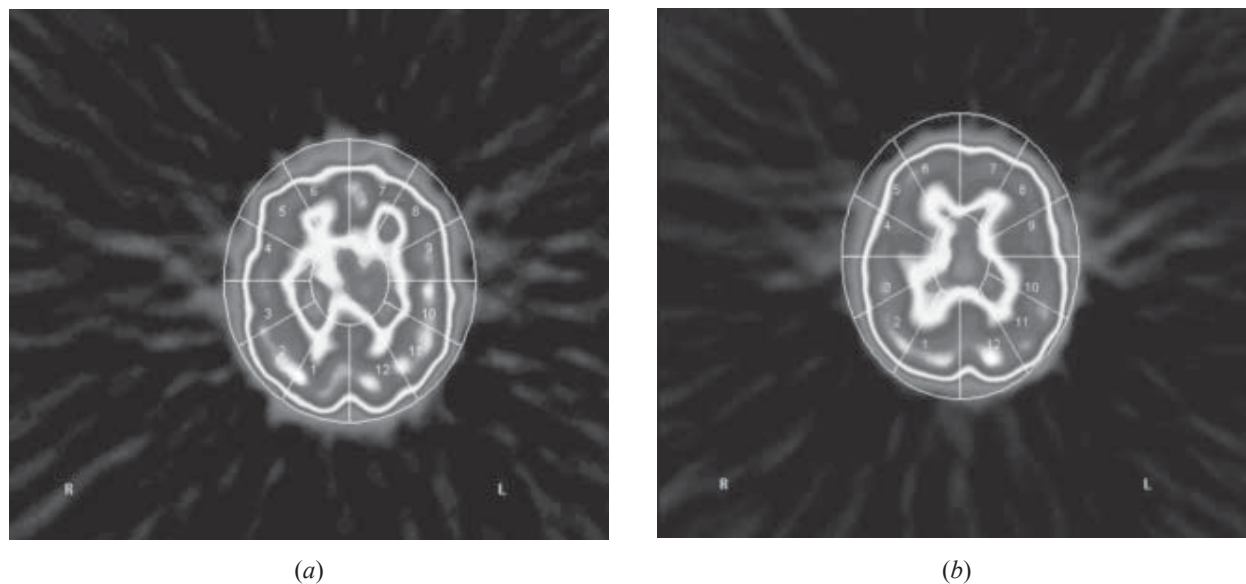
Quantitative segmental analysis of SPECT brain (a) Case of autism with mental retardation; (b) Control.
